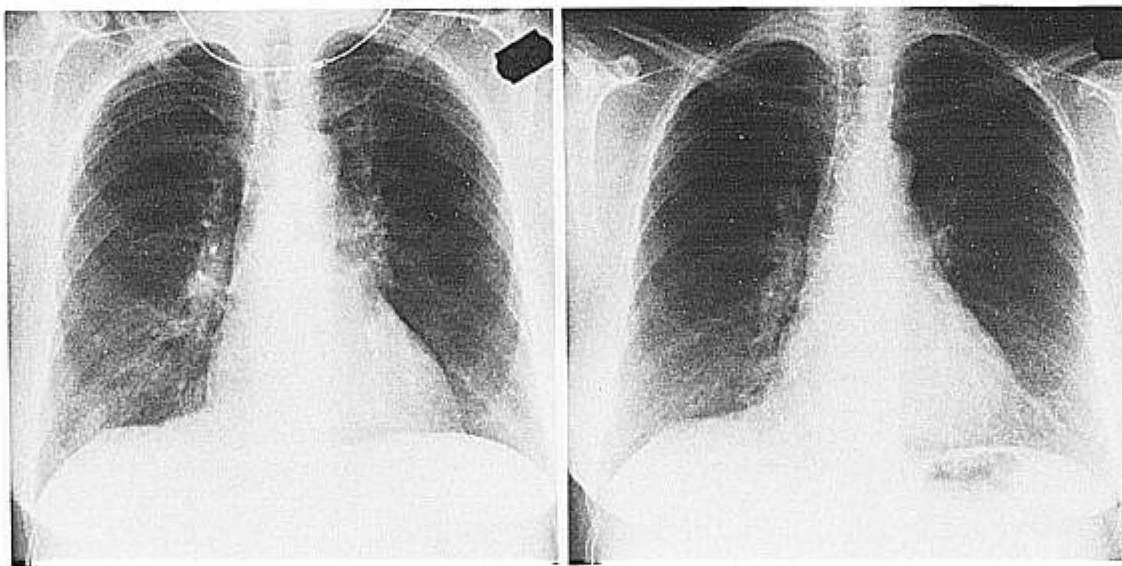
Adenoviral pneumonia. (Left) Radiograph of a 54-year-old woman with bilateral interstitial and alveolar infiltrates and hilar adenopathy. (Right) Resolution of the process during convalescence.
